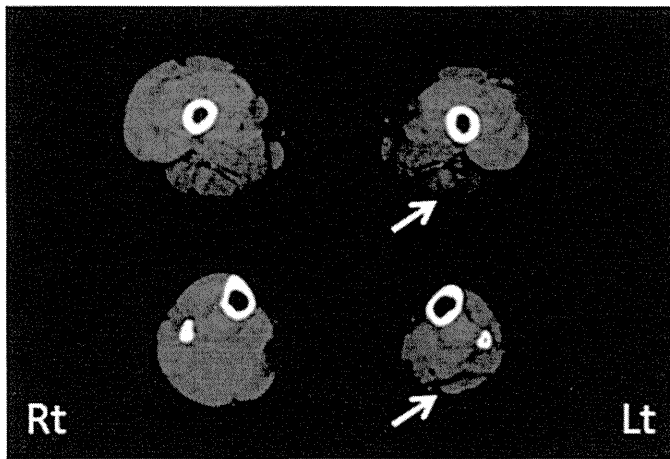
Muscle computed tomography of patient 2 at age 10 years revealing left-side dominant atrophy, especially in hamstring and gastrocnemius muscles (arrows).
